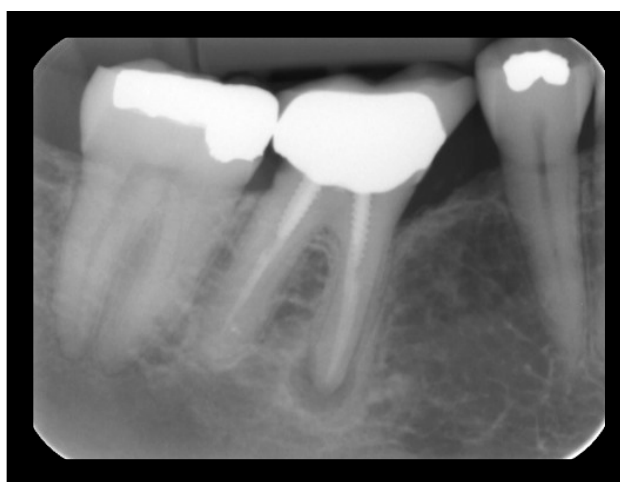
Periapical radiograph
